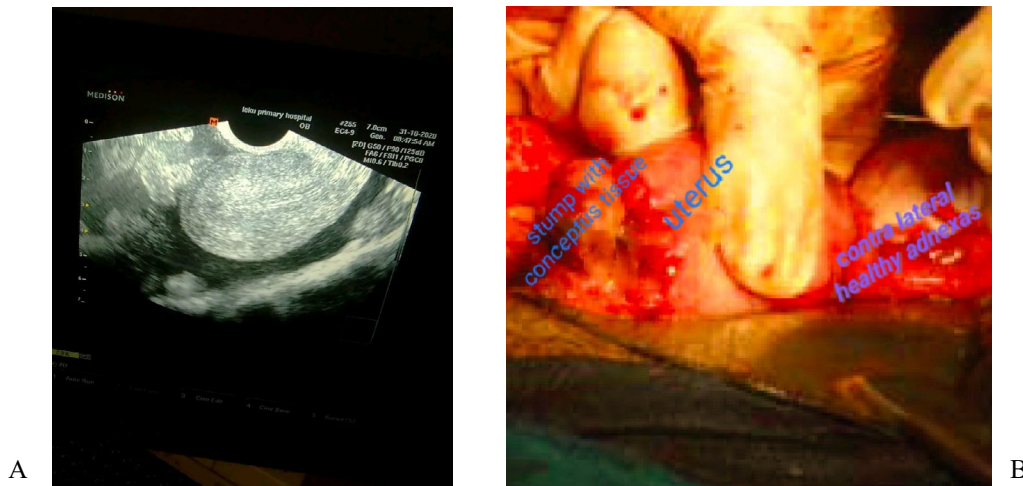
A -ultrasound image of ruptured ectopic with cul-de-sac collection and contained clot near the rt side of uterine edge, the uterus clearly seen empty. B-intra-operative image of the tubal stump ectopic pregnancy rupture.
